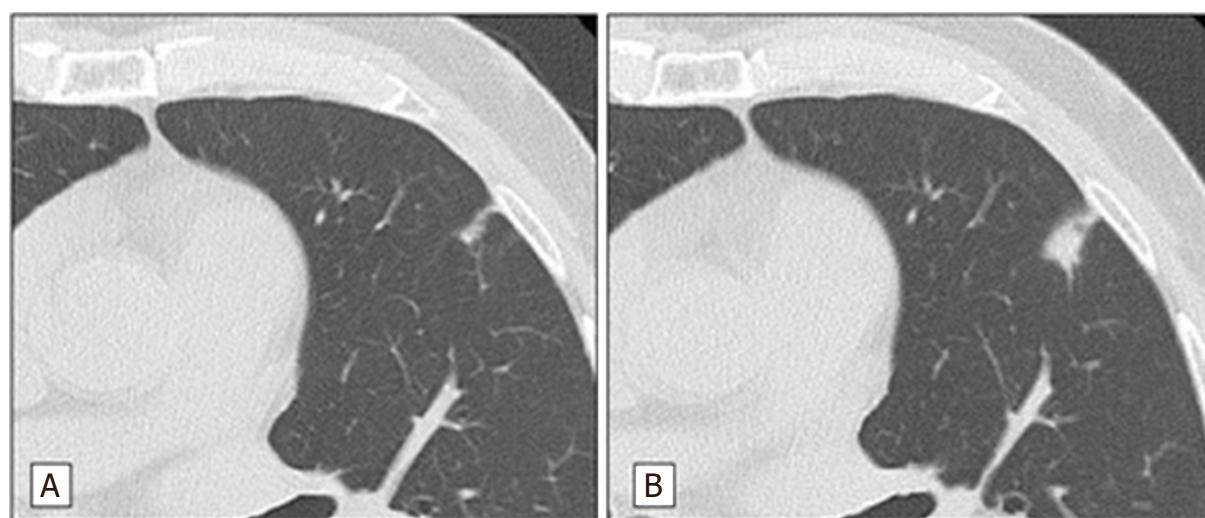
CT chest showing isolated pulmonary metastases initially diagnosed (A) 98 months after curative resection of PDAC and then (B) 108 months after curative resection of PDAC, showing that the nodule increased in size. The patient underwent wedge resection and received gemcitabine-based adjuvant chemotherapy for 6 months. The patient remained asymptomatic and tumor-free for a total of 4 years since last pulmonary metastasectomy^[40]. CT: computed tomography; PDAC: pancreatic ductal adenocarcinoma
